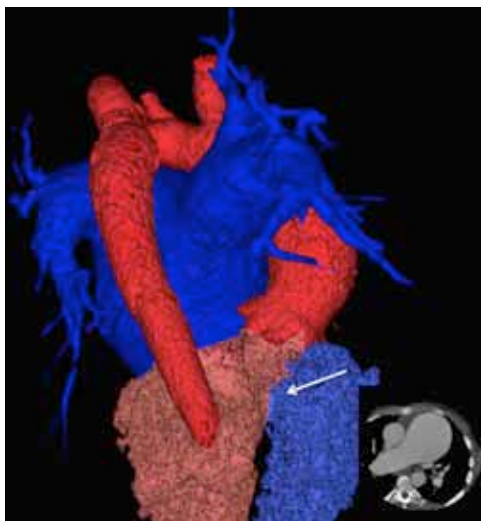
CT 3D reconstruction demonstrating distal pulmonary arterial pruning (blue) and perimembranous VSD (arrow).
